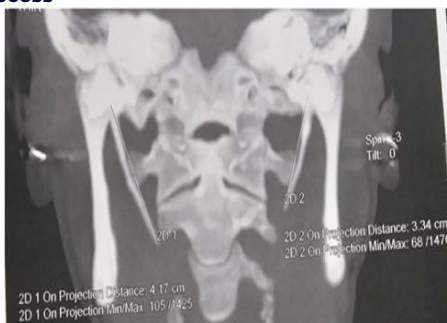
Coronal CT Showing Bilaterally Enlarged Styloid Process Approximately 4.17 cm on the Right and 3.34 cm on the Left
